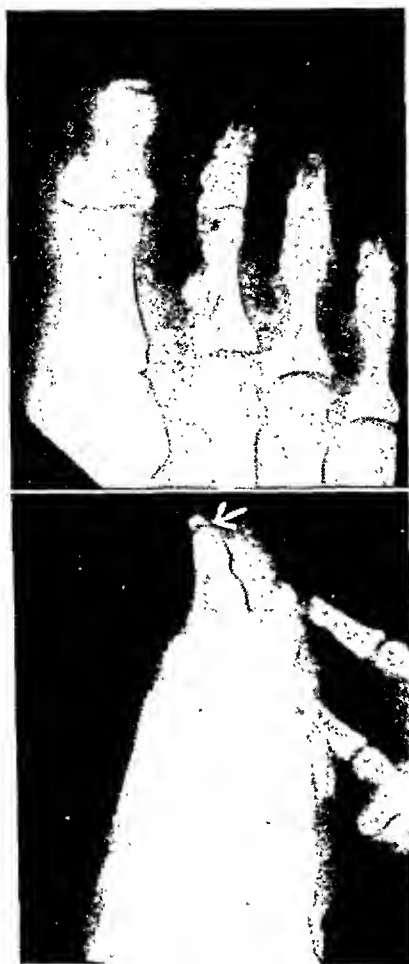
Case 11: Old, ununited, previously undiagnosed fracture of tip of distal phalanx. The patient had recently dropped a heavy object on the toes. A similar accident had occurred eight months earlier but no x-ray examination was done.
